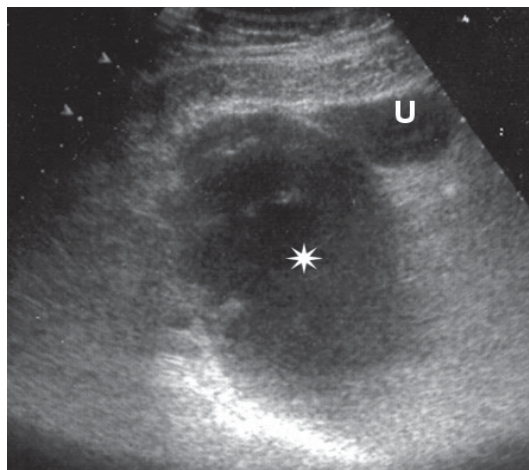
Ultrasonography. Transabdominal approach. Pyosalpinx. The uterine tube (asterisk) is distended with corpuscular liquid. *U*, uterus
